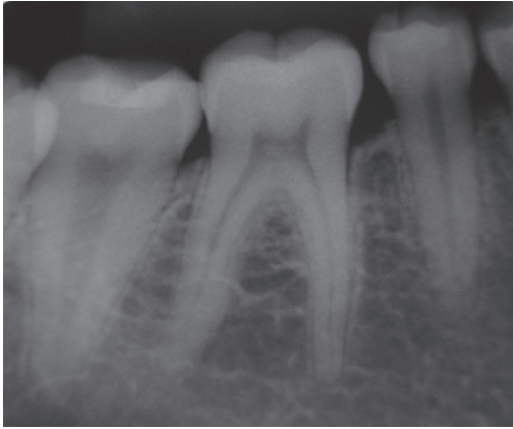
Periapical radiograph showing small crestal bone loss in the region
